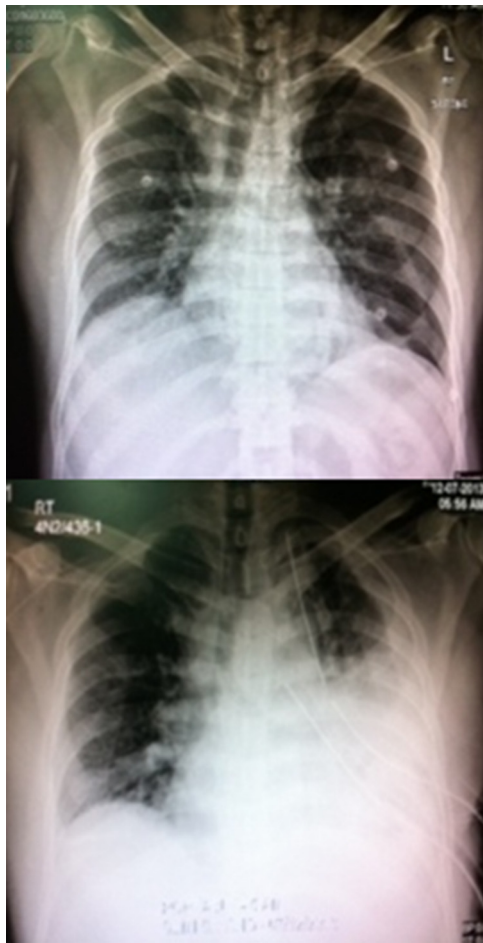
The initial chest X-ray showing pneumothorax (upper panel) and after chest tubes insertion after thoracotomy and developing effusion (lower panel).
